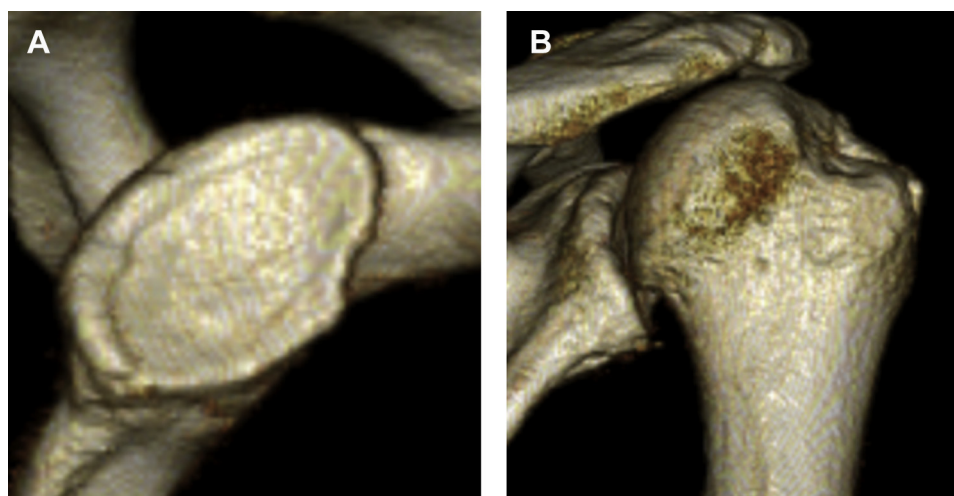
Three-dimensional computed tomography. (A) Glenoid. (B) Humeral head.
